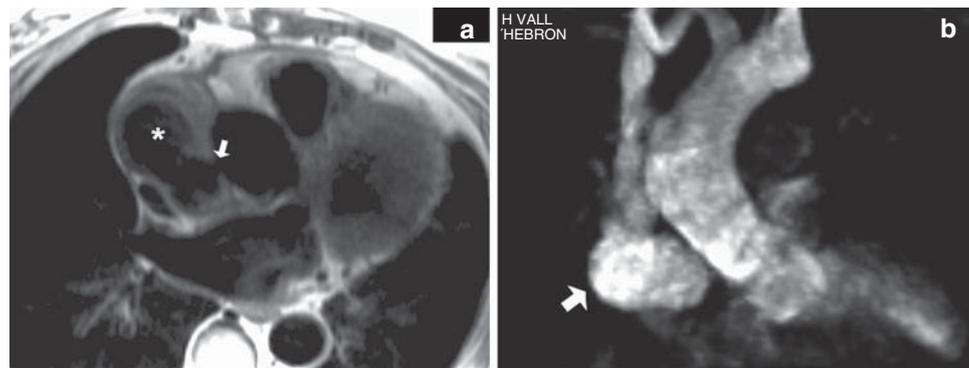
Surgically treated Type A aortic dissection. (a) Axial T1-weighted black-blood image shows a pseudoaneurysm (asterisk) communicated (arrow) with the ascending aorta. (b) Sagittal maximum-intensity-projection image from CE-MRA shows contrast filling of the pseudoaneurysm
